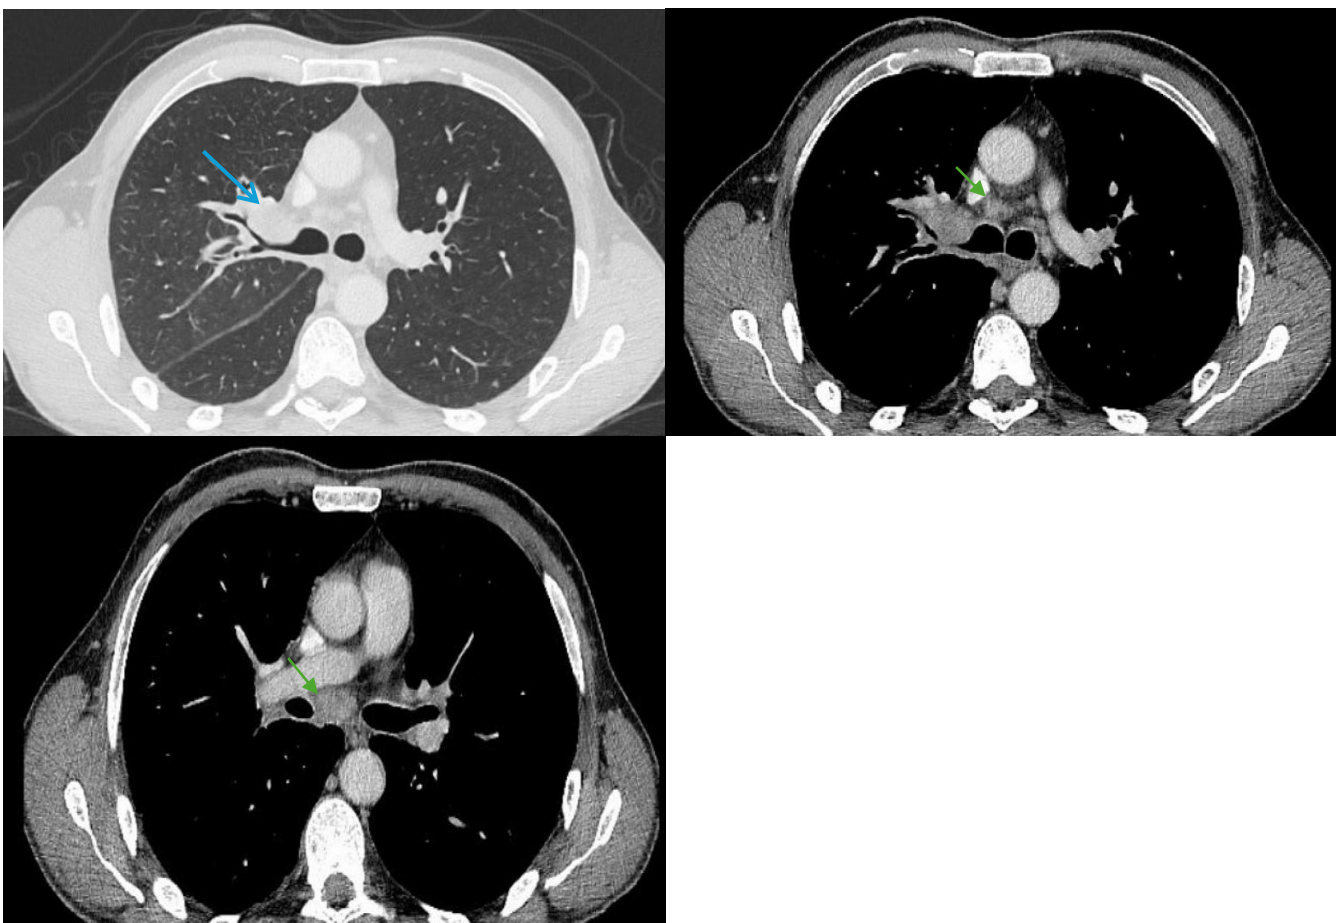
Chest CT scan (lung and mediastinal windows) showing 2.6×3.7 cm right perihilar lesion (blue arrow). Multiple mediastinal lymph nodes are noted in the precarinal and subcarinal spaces (green arrows).
